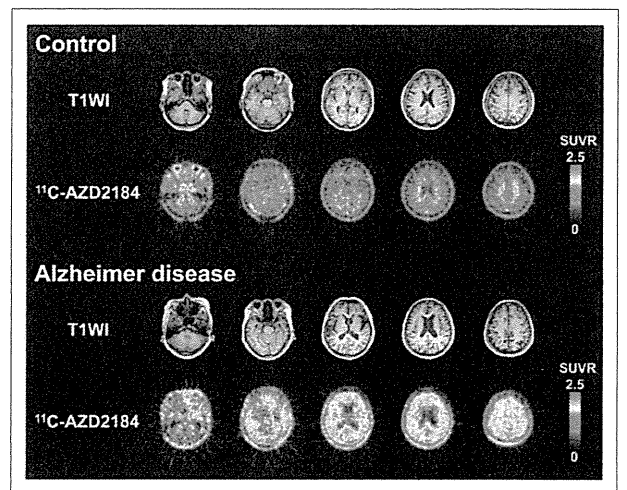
Representative SUVR images of ¹¹C-AZD2184 binding in control subject and AD patient. Integration interval was 40–60 min. Corresponding MR images (T1-weighted [T1WI]) are shown. Scale maximum and minimum values are 2.5 and 0 of SUVR. All images are transaxial sections, and anterior is at top of image and subjects' right is at left.
